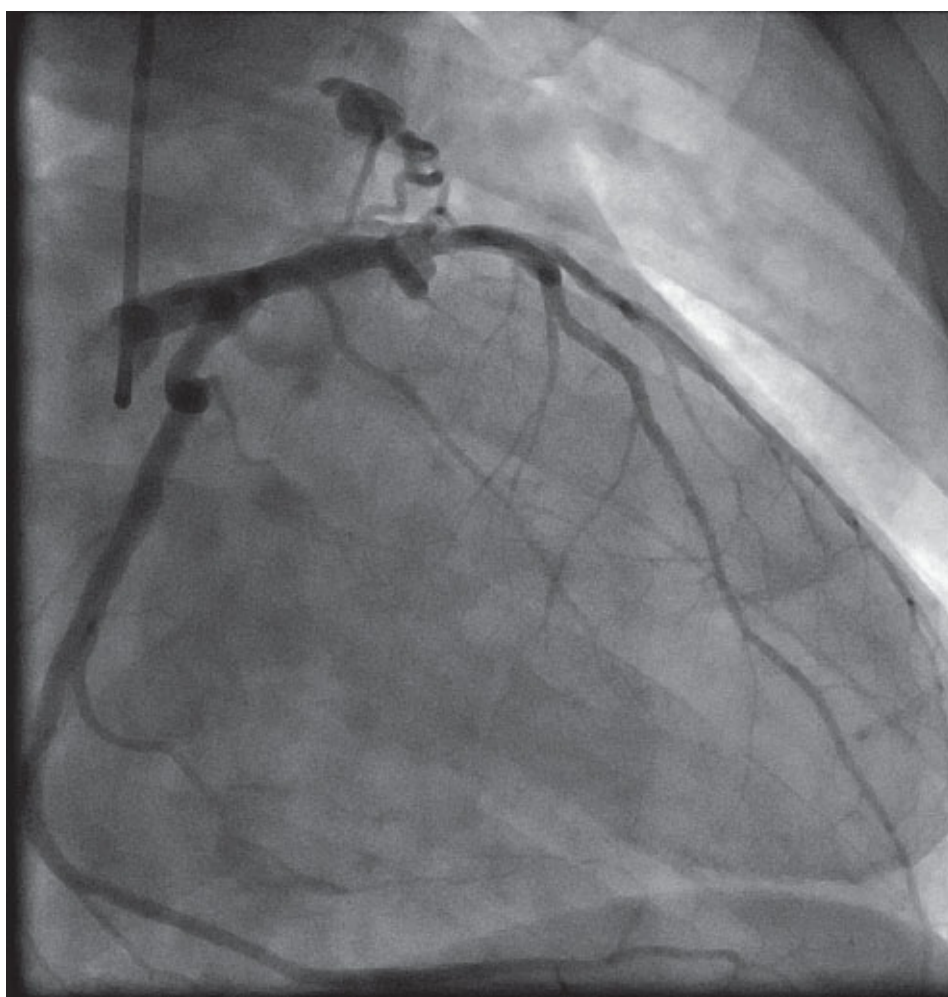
A 38-year-old man who presented with exertional substernal chest pain. He was evaluated with a nuclear stress test that revealed anterior reversible and septal ischemia. Coronary angiography revealed a right coronary artery to left anterior descending artery fistula. CT angiography confirmed the presence of a right coronary artery to left anterior descending artery fistula through a ventricular septal pseudoaneurysm. IVS, interventricular septum.
